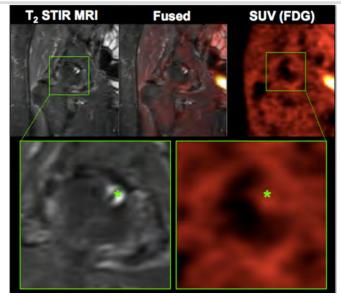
[18F]-FDG PET images in the hip of a 76-year old patient, co-registered and fused with T2-weighted STIR MRI. Asterisk indicates a cyst in the femoral head that appears topographically co-localized with increased tracer uptake on the FDG PET image.
